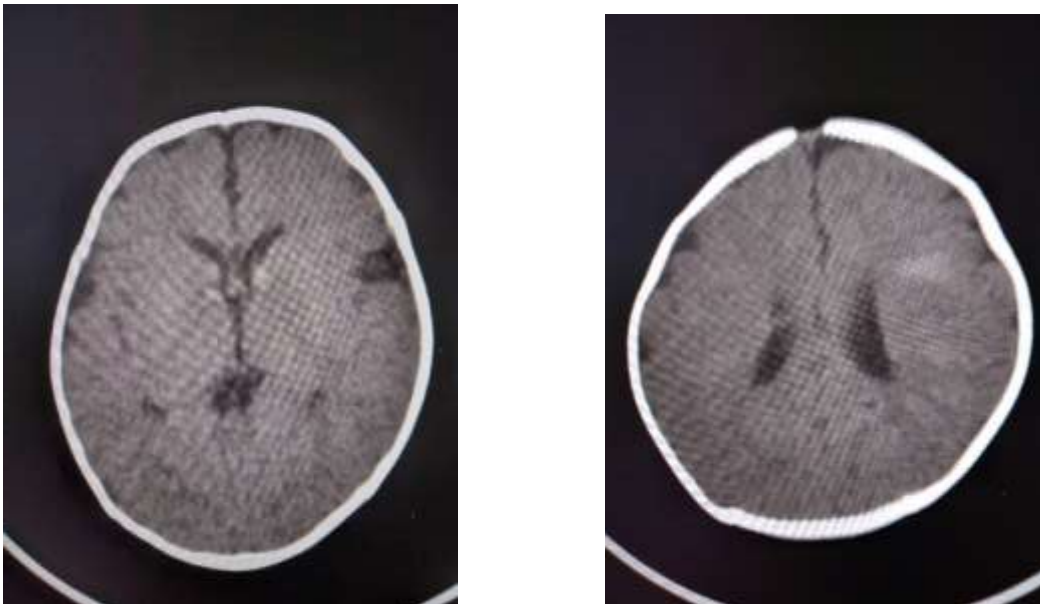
Axial CT sections without injection of contrastproducthighlightingsubependymal calcifications associatedwith a discreetwidening of bilateralcorticosubcorticalfurrows: appearance of tuberoussclerosis of Bournéville.
